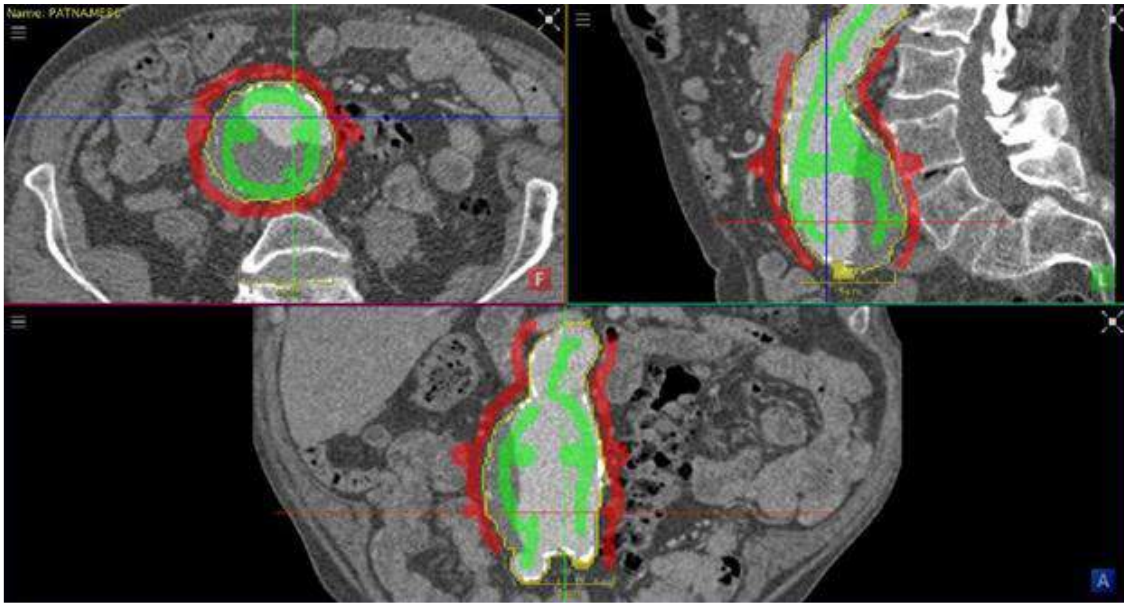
Initial segmentation process on CT images showing the boundaries of the AAA wall (yellow line) that will be segmented.[151]
